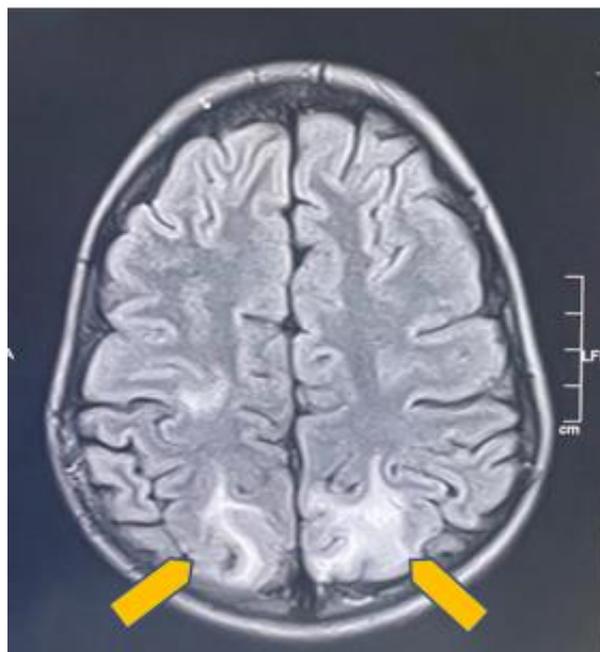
Cerebral MRI showing T2 hypersignal and flair related to bilateral parieto-occipital vasogenic edema evoking PRES (arrows)
